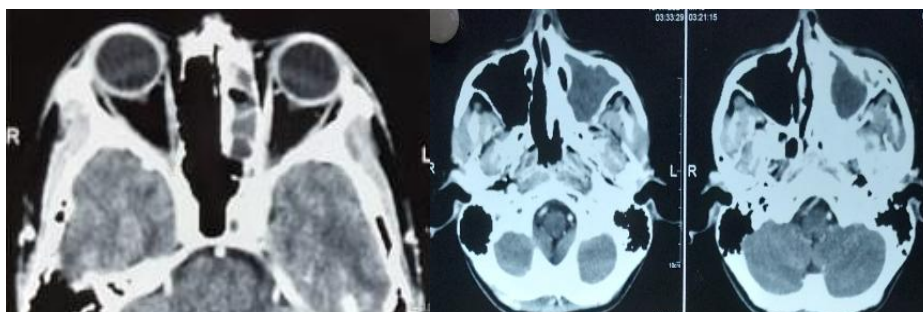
CT showing mucosal thickening involving left maxillary, ethmoid and frontal sinuses.
